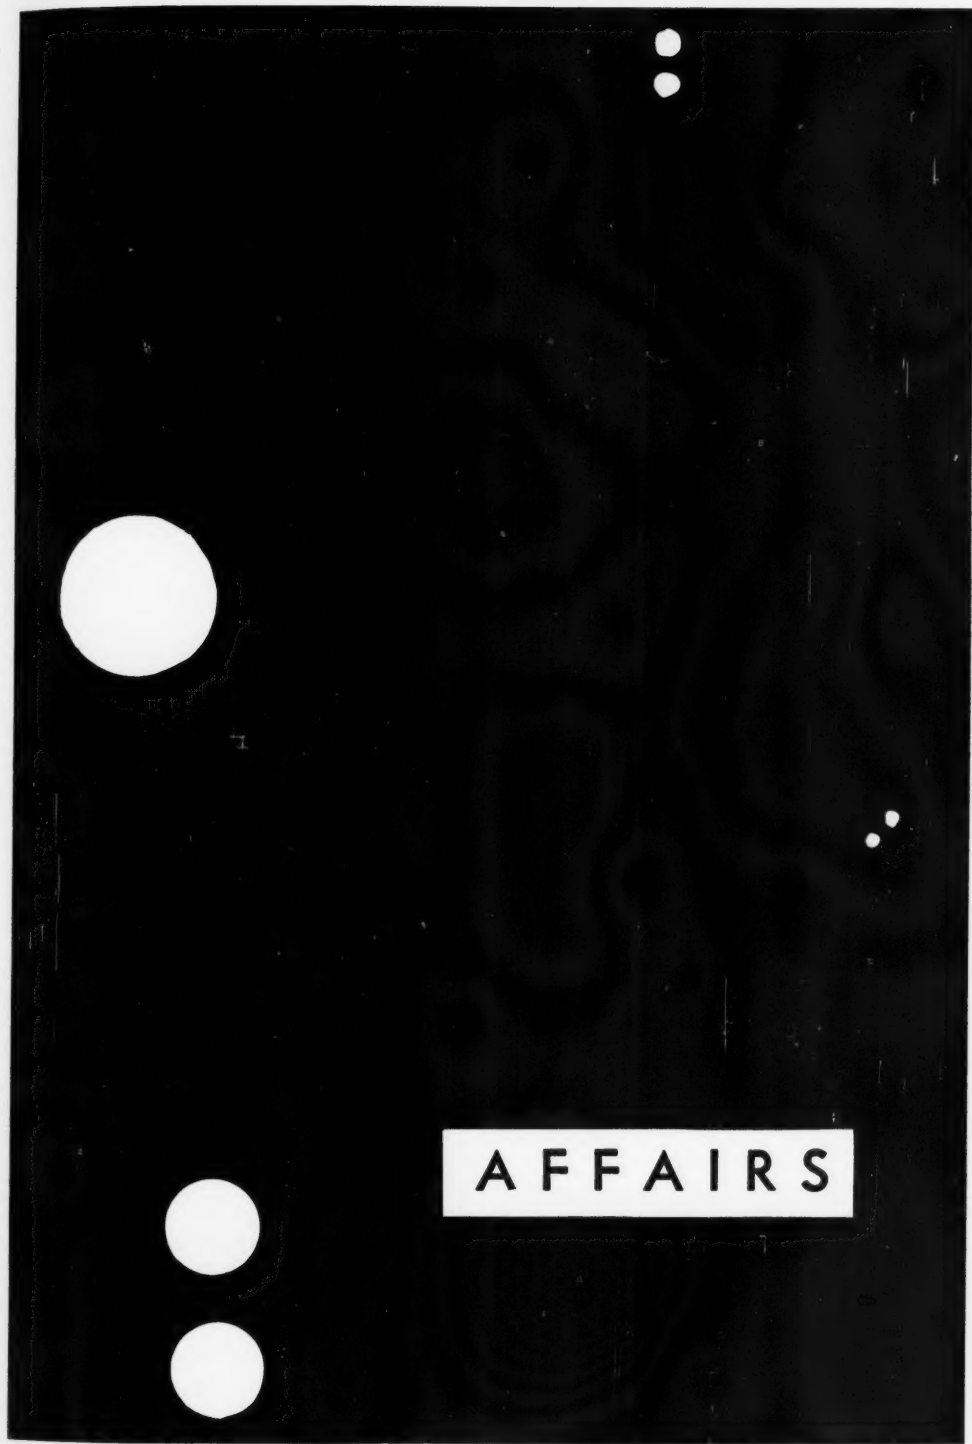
At 14-inch reading distance, this gives a retinal pattern equal to that of the x-ray stencil shown in Figure 2. Inset are letters equivalent to Snellen "20/200" for 14-inch reading distance.
